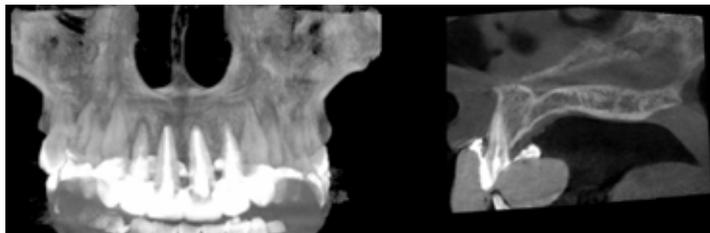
CBCT of the patient in front view and sagittal view before treatment.
